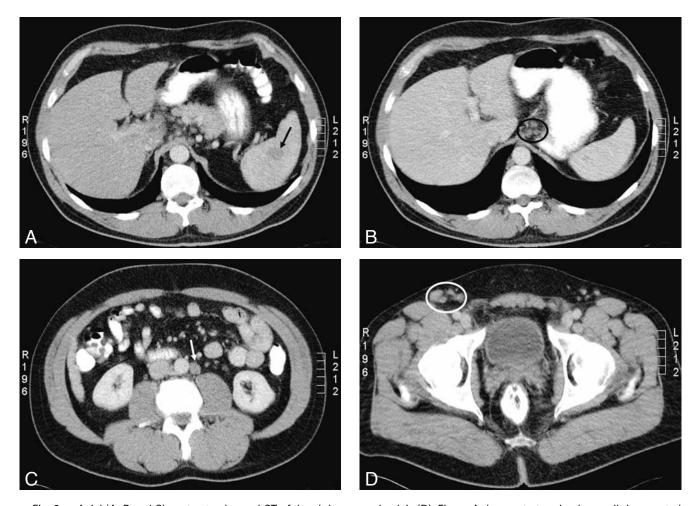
Axial (A, B and C) contrast-enhanced CT of the abdomen and pelvis (D). Figure A demonstrates clearly a well demarcated hypodense intrasplenic lesion 3 cm in size. Image B demonstrates multiple enlarged lymph nodes at the retroperitoneum and gastrohepatic ligament (circle) and image C an enlarged paraaortic lymph node (arrow). Figure D demonstrates the pathological lymph node aggregate (circle) in the right inguinal region from which the biopsy was obtained.
